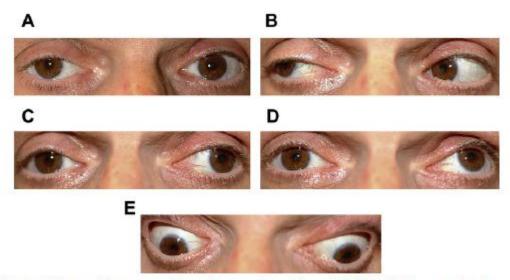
A 55-year-old woman with a microvasculopathic partial right third nerve palsy due to diabetes and hypertension. Magnetic resonance imaging and magnetic resonance angiography were normal. (A) Right ptosis without mydriasis in primary position. Mild physiologic anisocoria was present. (B) Normal right gaze. (C) Decreased right adduction on left gaze. (D) Decreased right elevation on upgaze. (E) Decreased right depression on downgaze. The motility became normal within 8 weeks.
